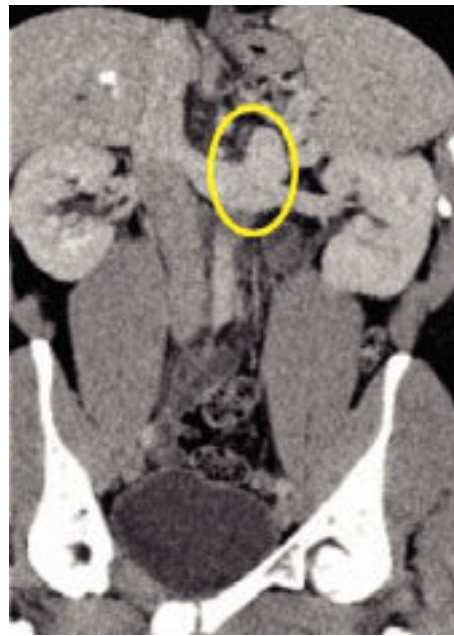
Computed tomography showing spontaneous splenorenal shunt.
